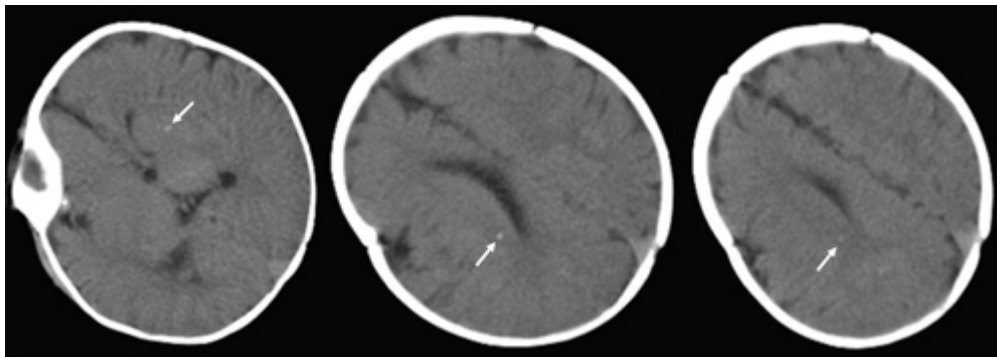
Brain CT showed bilateral a few calcifications (arrows) in the basal ganglia. [↩](#)
